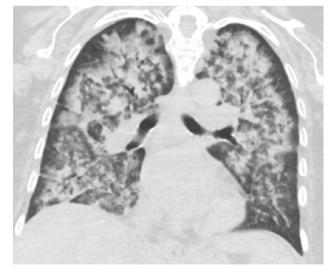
A 63-year old man with diffuse alveolar hemorrhage due to heart failure with preserved ejection fraction. The coronal computed tomographic image showed diffuse bilateral infiltrate affecting all lung lobes. The infiltrate(s) are characterized by both ground glass opacities and consolidation with air bronchograms. There are also areas on centrilobular nodularity and interlobular septal thickening. Additionally, subpleural sparing is a striking feature in this CT image
